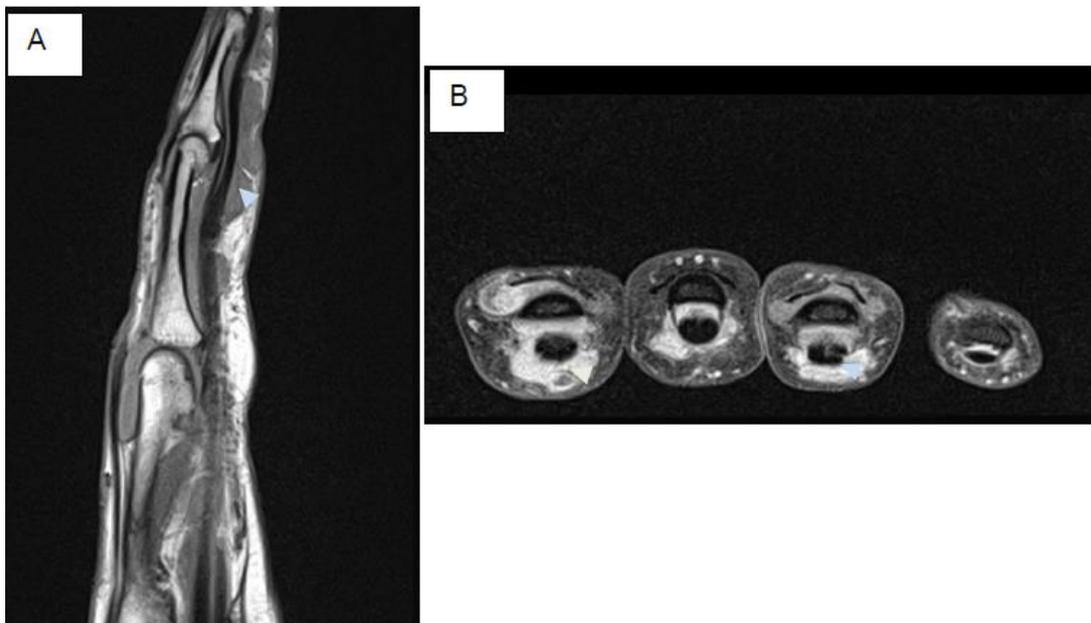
T1 MRI (2nd MCPJ), [a] sagittal and [b] axial contrast-enhanced T1 (level of MCPJs). Thickened synovium and tenosynovium (arrows) will show enhancement with IV contrast administration.
